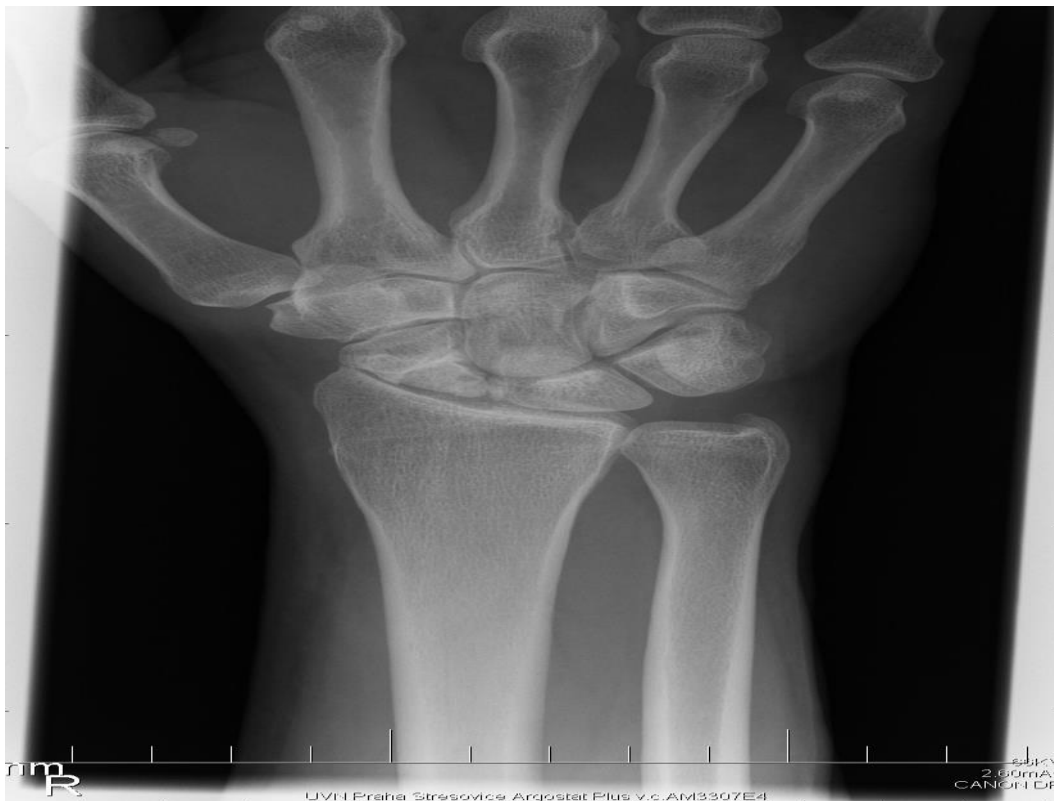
X-ray of right wrist in superior view (Personal image of my patient's wrist)
